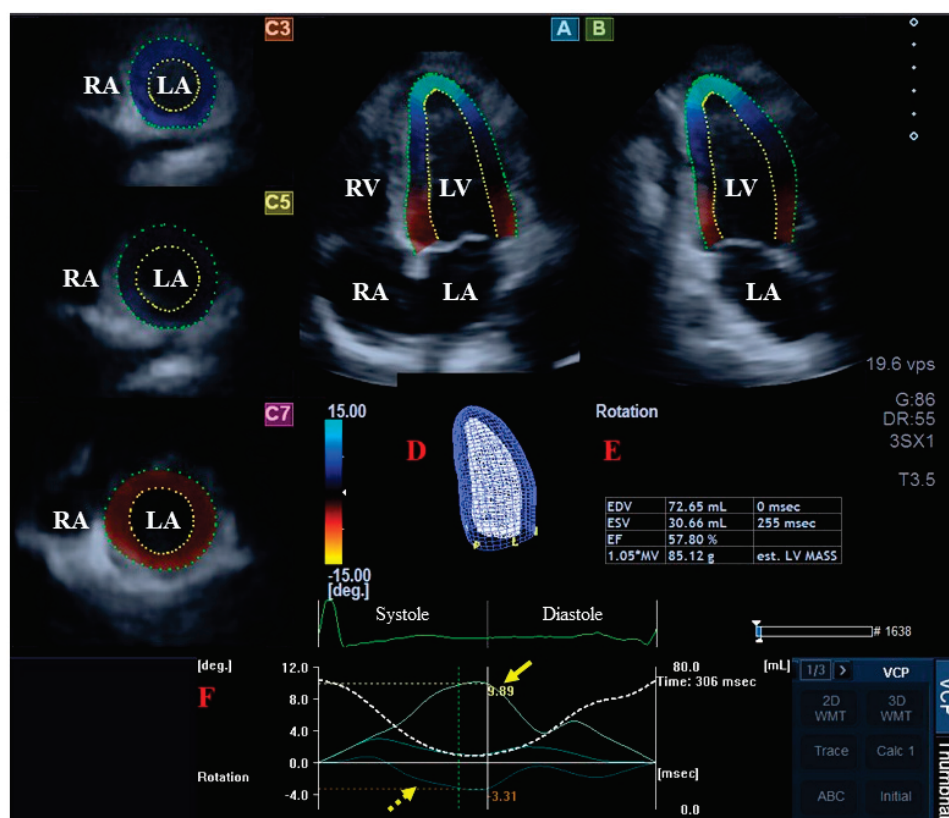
Three-dimensional (3D) speckle-tracking echocardiography-derived evaluation of the left ventricle (LV): apical four-chamber (A) and apical two-chamber long-axis views (B), and short-axis view at basal (C3), midventricular (C5) and apical LV levels (C7) are demonstrated together with a 3D cast of the LV (D) and calculated LV volumetric data (E). Apical (yellow arrow) and basal LV rotational curves (dashed yellow arrow) together with LV volume change curve during the heart cycle (dashed white curve) (F). Abbreviations. EDV, end-diastolic volume; EF, ejection fraction; ESV, end-systolic volume; LA, left atrium; LV, left ventricle; RA, right atrium; RV, right ventricle.
